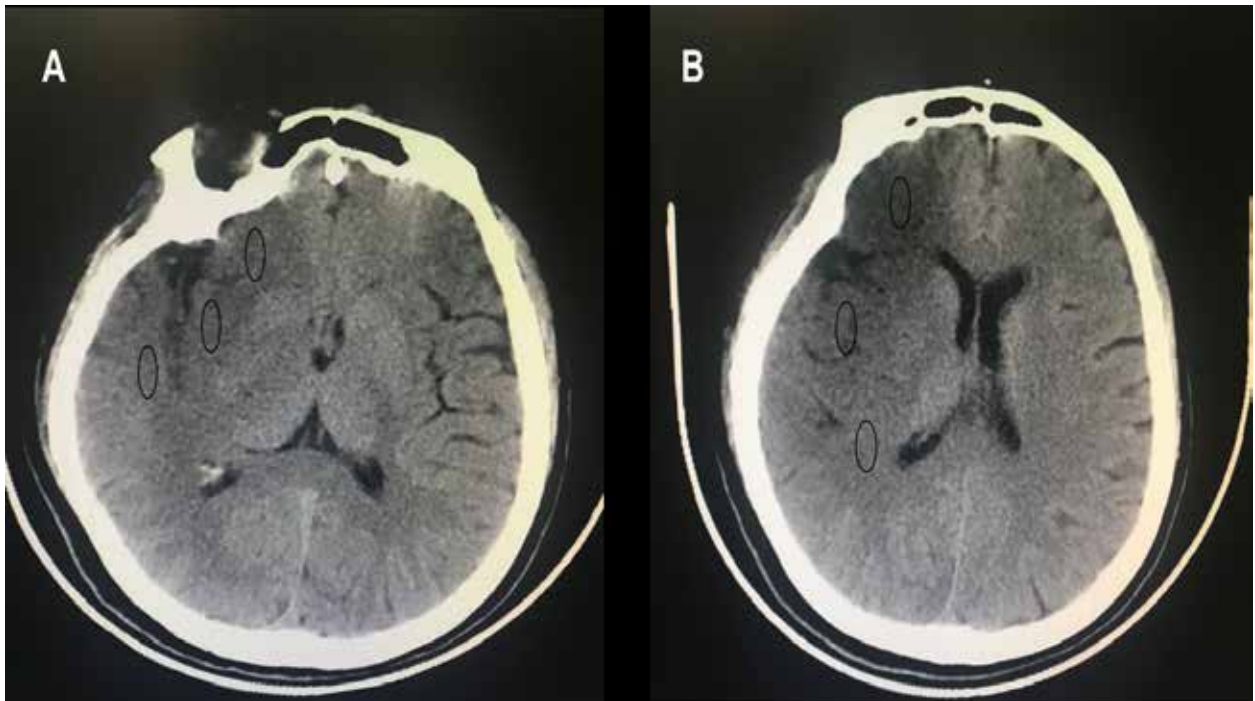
CT images of 60-year-old female with cerebral infarction at one-hour onset. Findings: Unenhanced brain CT imaging, axial section at level of basal ganglia on left image and at supraganglionic level on right image. There is hypodensity in the insular cortex, M1, M2, M4, M5, and M6 regions on the left side, resulting in ASPECTS of 4.
